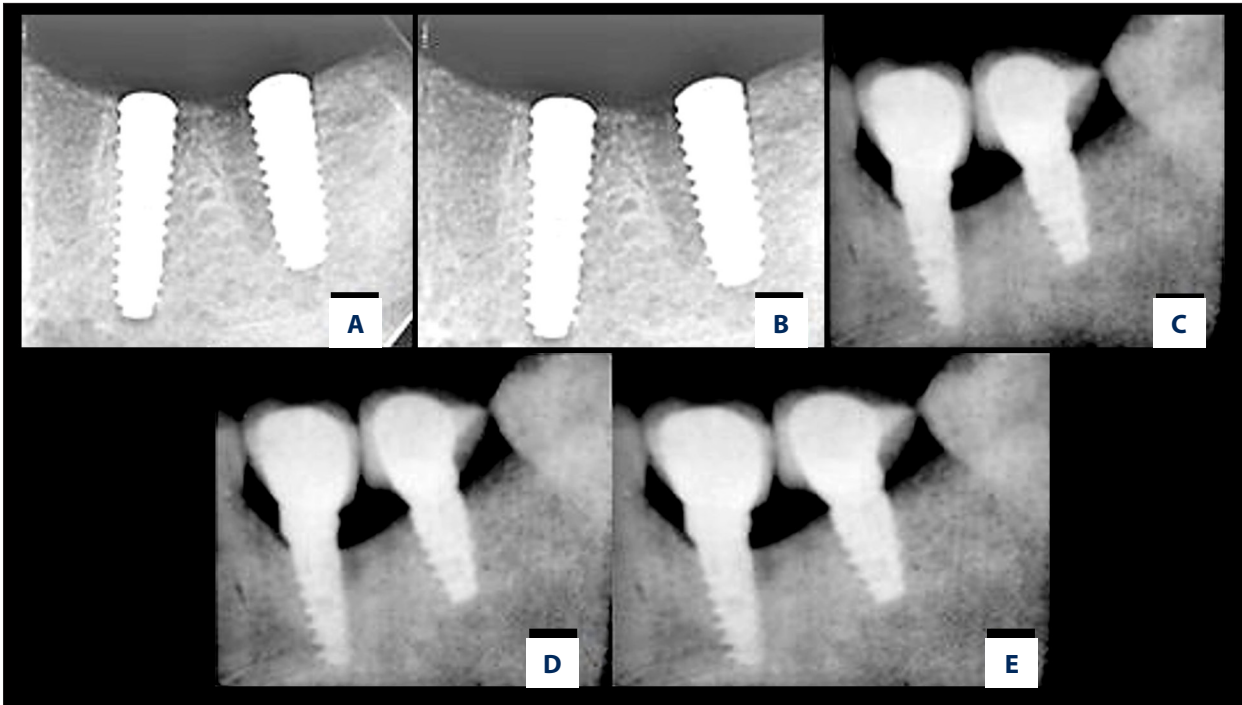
Radiographic interpretation of equicrestal implant placement (A) At the time of placement (B) At 3 months (C) At 6 months (D) At 9 months (E) At 12 months. *Figure created using MS PowerPoint, version 20H2 (OS build 19042,1466), Windows 11 Pro, Microsoft corporation).*
